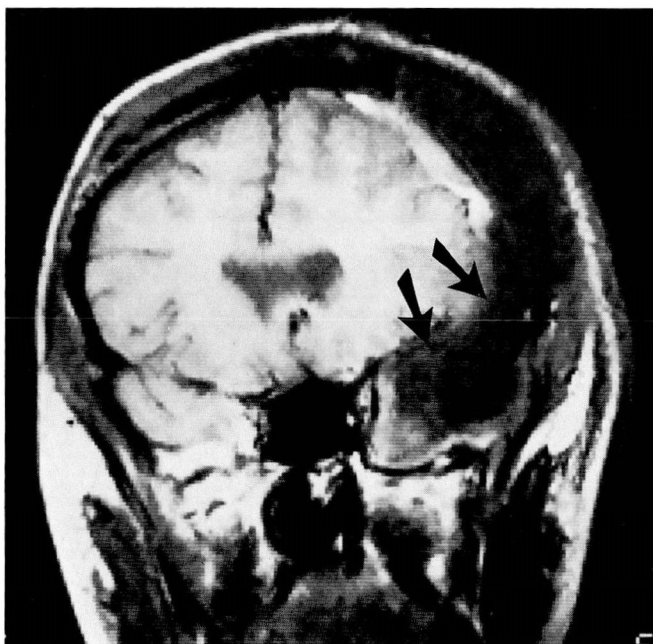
Coronal MR image (1.5 Tesla, TR=600, TE=32 ms) obtained before omental transposition, showing wound empyema (arrows) involving the sylvian arachnoid cyst.
